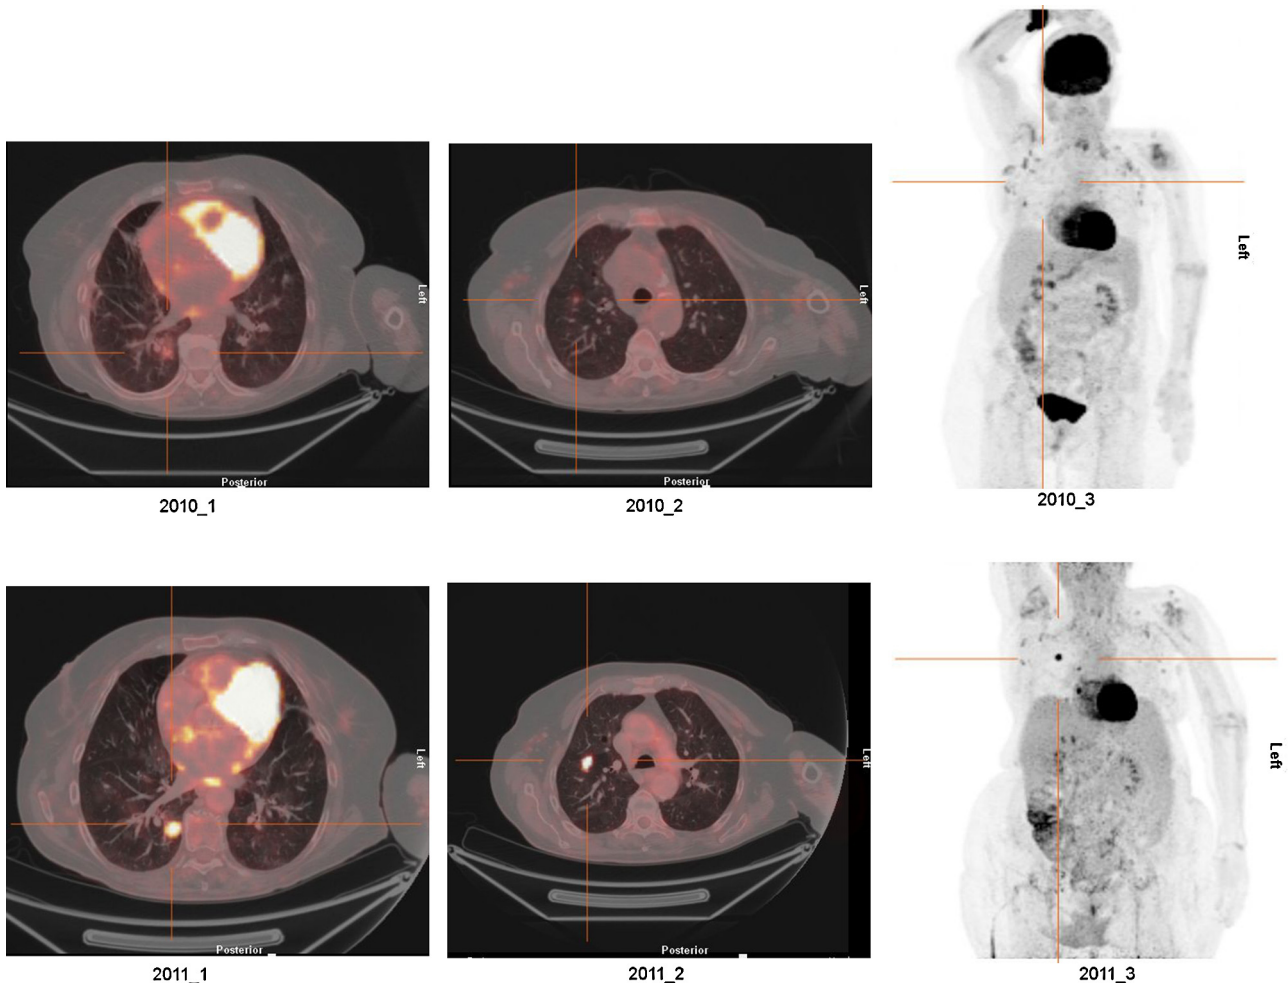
(A) Images taken in 2010. The CT scans show enlarged lymph nodes in the axillae, periclavicular and mediastinal areas, and splenomegaly and bullae in the lungs. The PET-CT shows activity in the right lung parenchyma, upper and lower lobe, and both shoulders. (B) Images taken in 2011. The PET-CT shows new round infiltrates in both lungs; the sizes of the multiple enlarged lymph nodes are unchanged and new enlarged lymph nodes have appeared alongside the iliac vessels.
